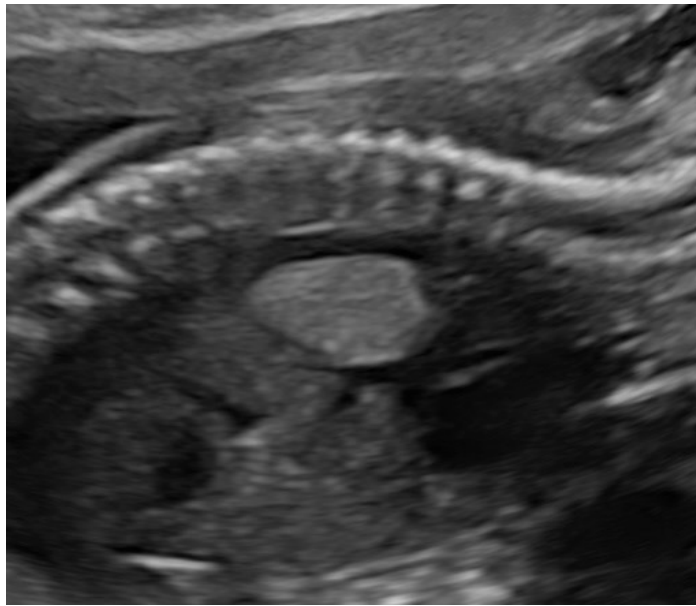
Bronchopulmonary Sequestration. Ultrasound (Sagittal plane).
